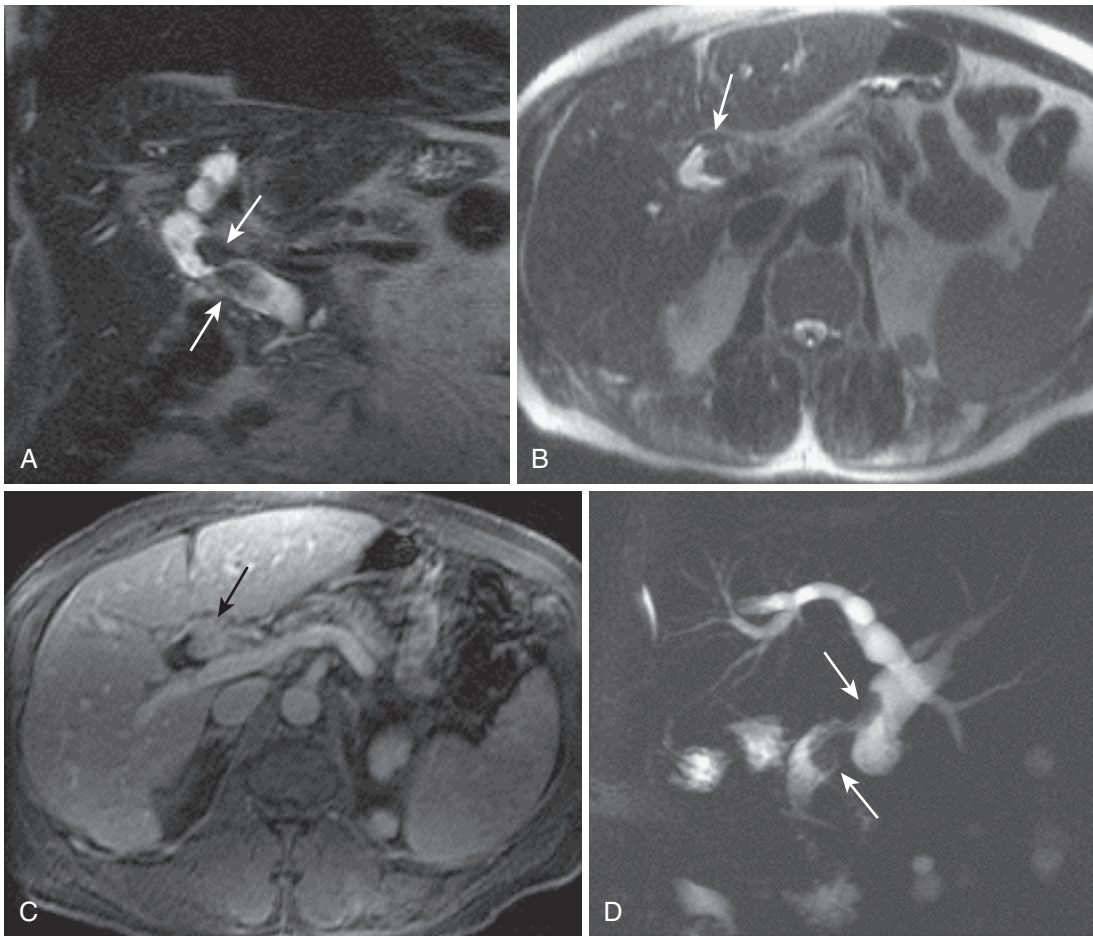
Cholangiocarcinoma with intraductal growth pattern. The coronal (A) and axial (B) heavily T2-weighted images depict hypointense irregular filling defects in the CBD (*arrows*) with enhancement revealed on the postcontrast image (C), indicating solid tissue in this uncommon case of extrahepatic, intraductal, mass-forming cholangiocarcinoma (*arrow*). D, MRCP shows stricturing of the CBD with upstream biliary dilatation (*arrows*).
